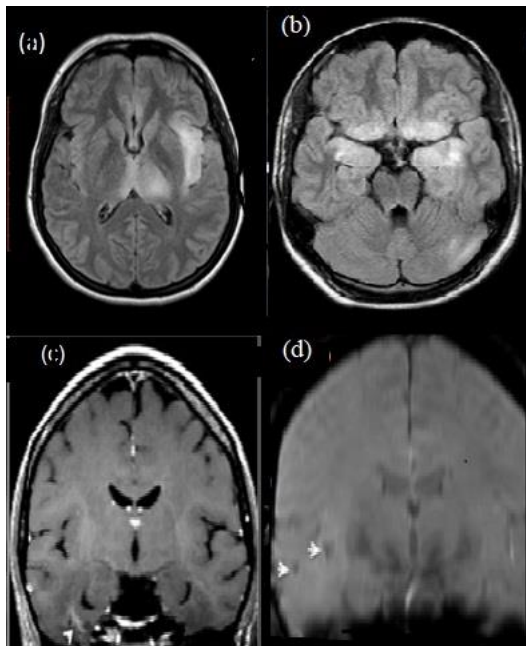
HSV Encephalitis: Axial T2/FLAIR image shows hyperintense signal in left insular cortex and thalamus (a), in bilateral inferior frontal lobes, medial temporal lobes, basal ganglia and insular cortex (b) , contrast enhancement in Rt temporal lobe on T1W1 postcontrast image (c), Foci of blooming in temporal lobe on T2* coronal image (d).
